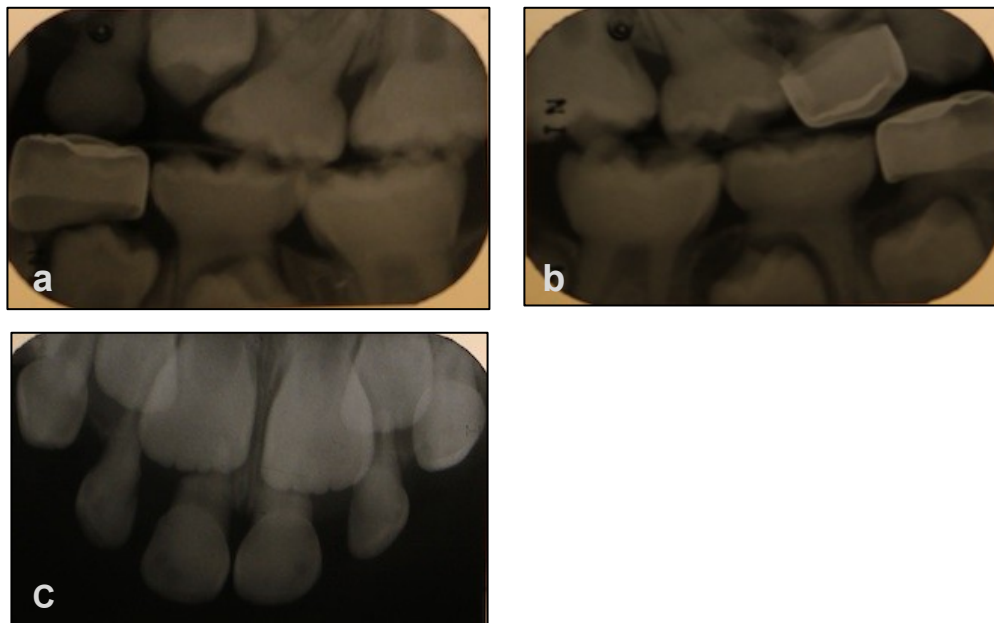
a) and b) are the left and bitewings of a DI type II patient (ID=30) showing primary molars with almost complete obliterated canals. c) and d) are the upper and lower anterior occlusal views. Primary incisors have small canals
